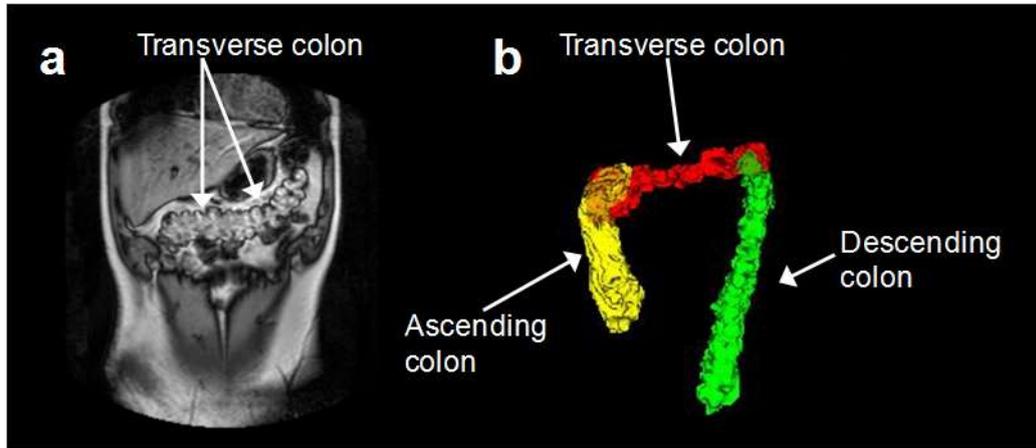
(a) Coronal ‘dual FFE’ MRI image of the transverse colon of a healthy volunteer taken at fasted baseline. (b) Three-dimensional reconstruction of the different regions (ascending, transverse and descending) of the colon of another healthy volunteer.
